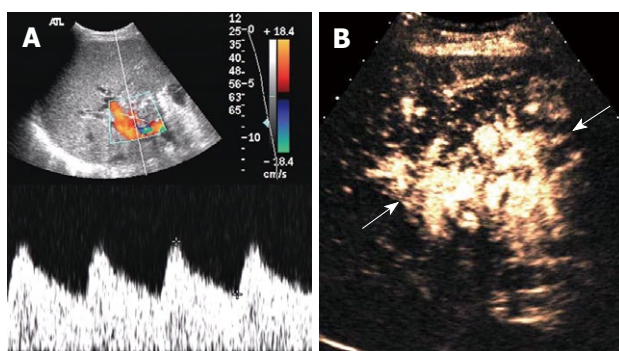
Hepatic artery obstruction with collateral circulation in a 36-year-old man who underwent RLDLT. A: Longitudinal oblique Doppler US scan 6 mo after RLDLT revealed a tardus-parvus spectrum at the porta hepatis; B: Longitudinal oblique CEUS scan obtained following the Doppler scan. A reticulate vessel instead of the right hepatic artery trunk was seen (arrows) at the porta hepatis after ultrasound agent injection.
